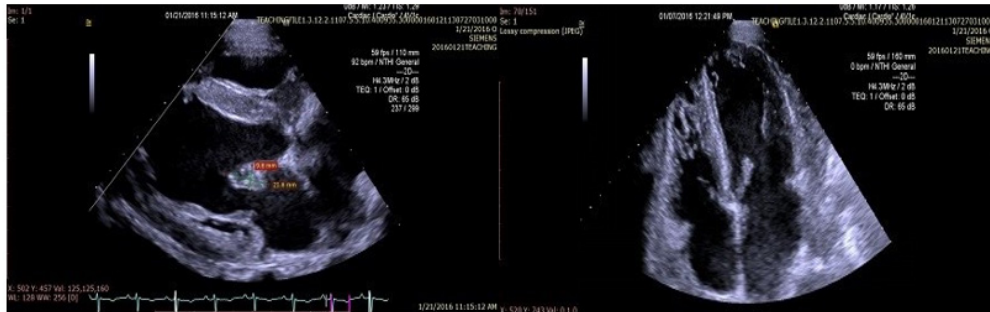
Diffuse infiltration of the anterior leaflet of the mitral valve with nodular thickening in the parasternal and apical 4-chamber view.
